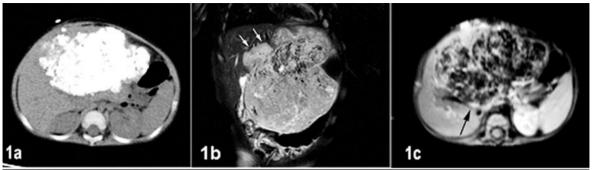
Unanehanced CT of liver (a) shows calcified mass of the liver involving left lobe. Coronal T2 weighted MR image (b) demonstrates portal hilar involvement of the mass (arrows). Contrast enhanced T1 weighted MRI reveales (c) portal hilar compression with vascular displacement (arrows).
